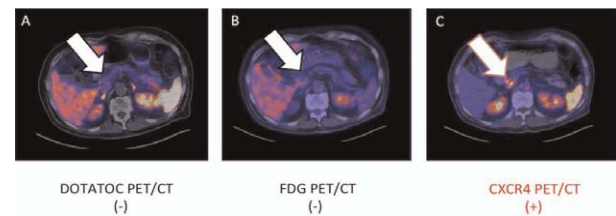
DOTATOC (A), FDG (B) and pentixafor/CXCR4 (c) PET/CT of a 69-year old male patient suffering from a pancreatic NET with a Ki67 Of 85%. Papilla of the pancreas demonstrated neither uptake in the DOTATOC nor in the FDG PET/CT (black arrows) whereas a Pentixafor scan was positive (red arrow)
